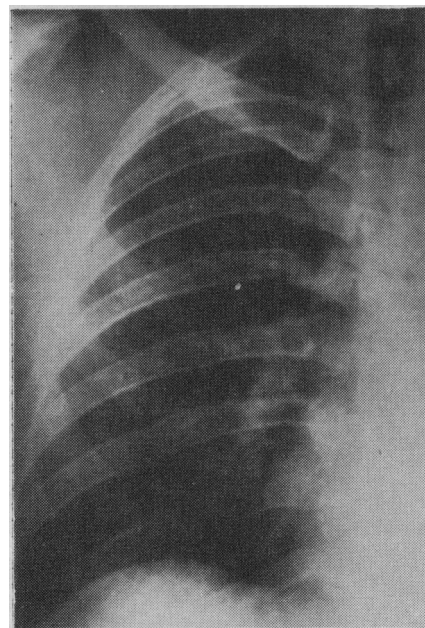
Enlarged view of right lung field of radiograph in Fig. 1.
